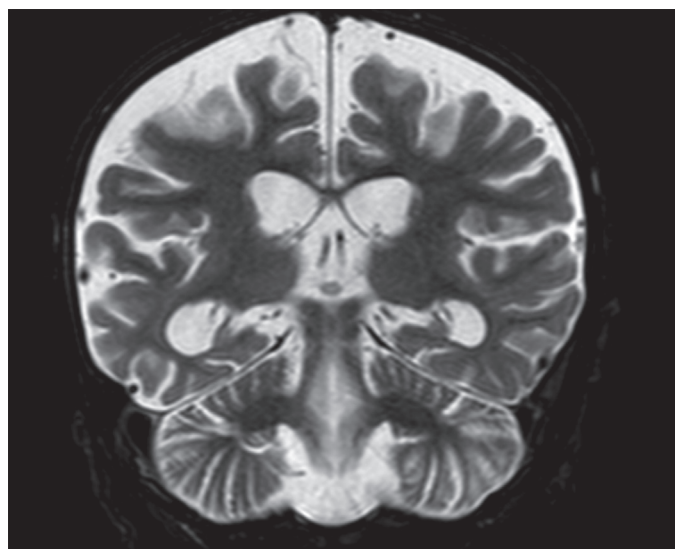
Cerebral and cerebellar atrophy in T2-weighted cranial magnetic resonance images
